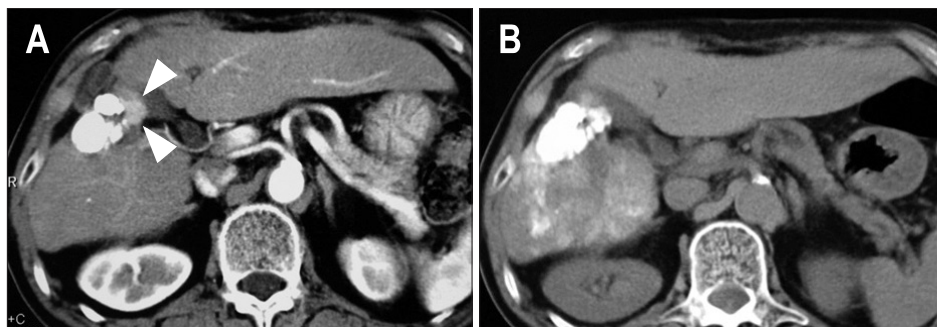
At 13 months after the first treatment, local relapse (arrowheads) was observed on follow-up computed tomography (A), and increased lipiodol accumulation was observed after the second transcatheter arterial chemoembolization (B).
